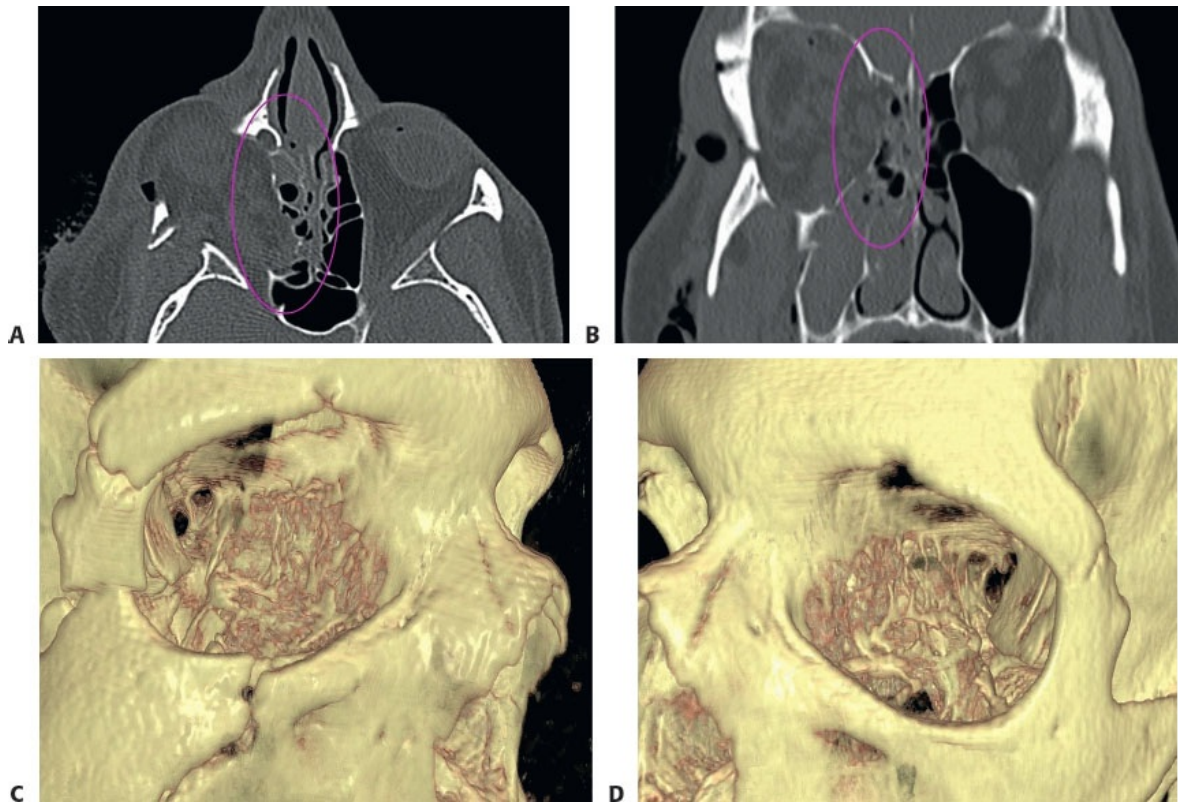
• Axial (A) and coronal (B) computed tomography (CT) imaging of the orbit demonstrating fracture of the (*right*) medial orbital wall with herniation of periorbital soft tissues into the ethmoid sinus (*circled*). C,D. 3D rendering of the same injury does not provide a detailed anatomic picture.
